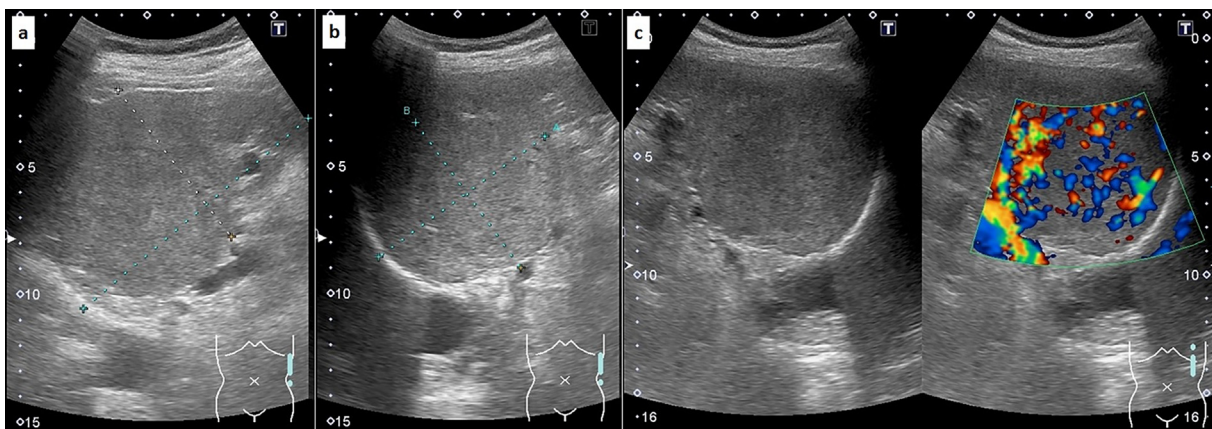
Ultrasonography showed splenomegaly (10.8 × 6.6 cm), with a solid, hypoechoic splenic mass (8.0 × 7.0 cm) (Fig. 1a, b). Color doppler ultrasound showed blood flow within the mass (Fig. 1c).
